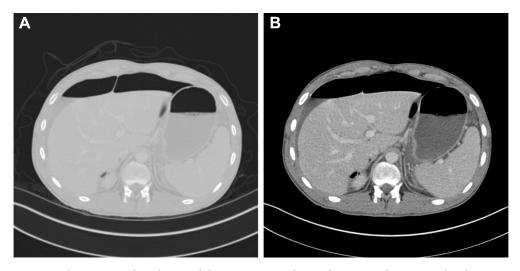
(A, B) Pneumoperitoneum and ascites. Axial IV-contrast-enhanced computed tomography demonstrates pneumoperitoneum (A) anterior to the liver and ascites (B) of uncertain etiology at the time of imaging.
